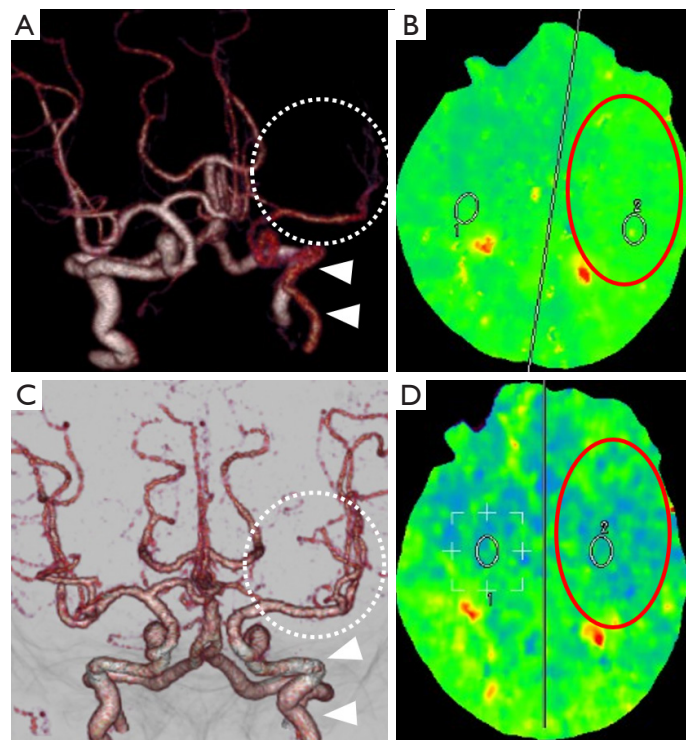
Rile's type 1A left common carotid artery occlusion in a 54-year-old woman. (A) In the preoperative head CTA, the arrows indicate the left internal carotid artery and the circle indicates its branches; (B) in the preoperative CTP, the oval indicates the extended MTT; (C) after ring-stripping hybrid operation, the arrows indicate the left internal carotid artery and the circle indicates its branches in CTA; (D) in the postoperative CTP, the oval indicates the improved MTT. CTA, computed tomography angiography; CTP, computed tomography perfusion; MTT, mean transit time.
